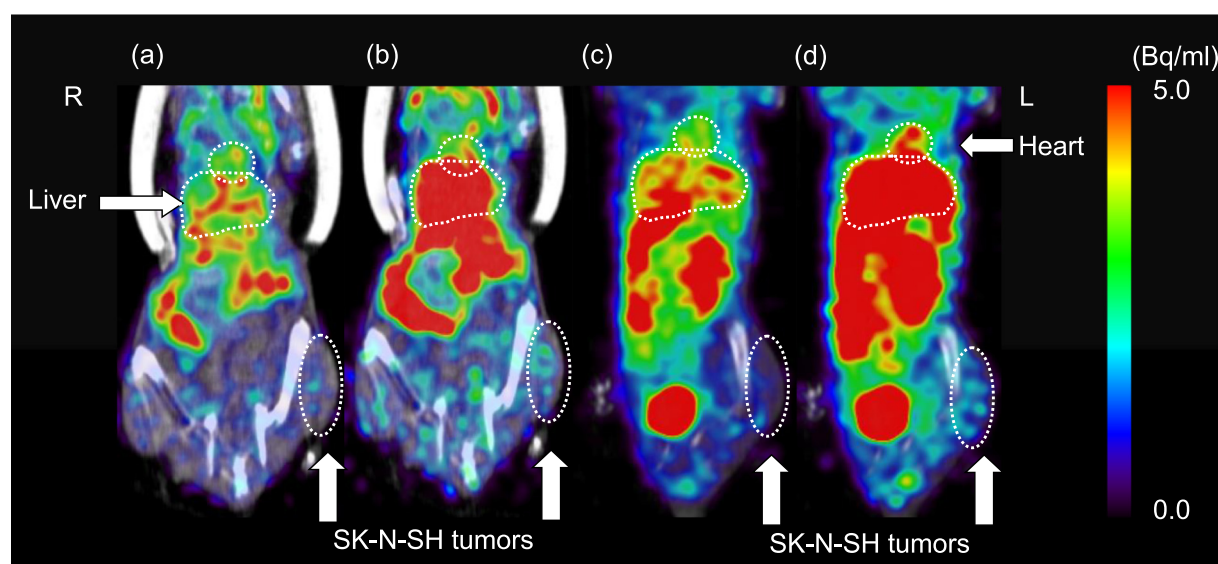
Representative [ $^{123}\text{I}$ ]MIBG SPECT imaging without (a, c) and with probenecid loading (b, d) at 10–15 min (a, b) and 60–65 min (c, d) after administration.
